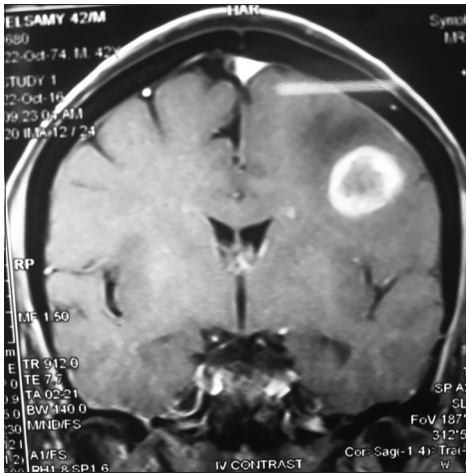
Magnetic resonance imaging brain showing lesion with thick irregular margin
